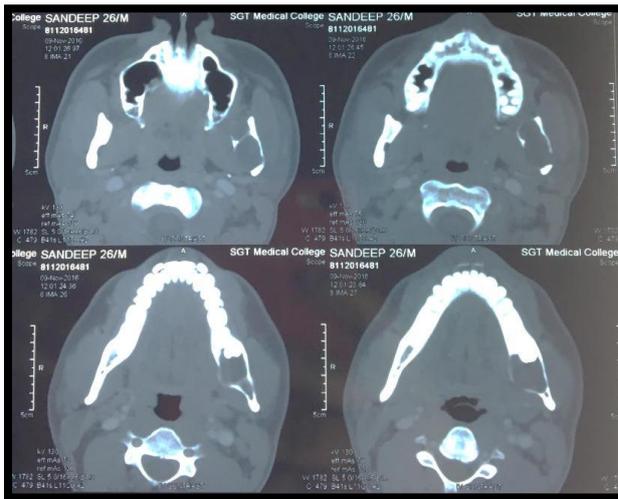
Axial CT Scans multilocular radiolucency with impacted 38
